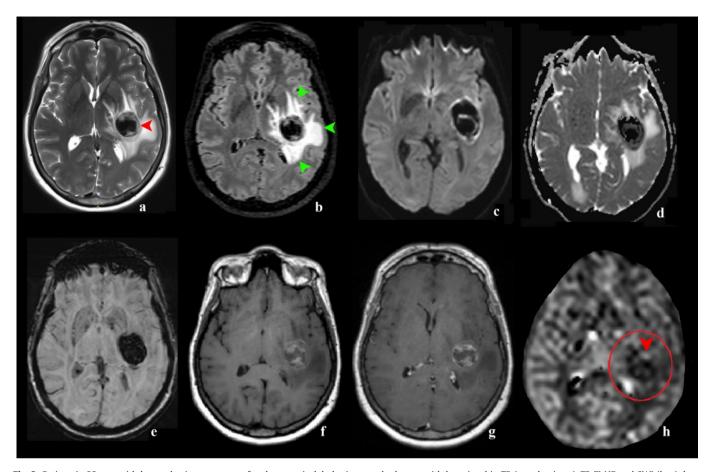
Patient A., 32 y.o., with hemorrhagic metastases of melanoma. A globular intracerebral mass with low signal in T2 (a, red pointer), T2 FLAIR and SWI (b, e) due to biological products that detect hemoglobin in the acute and early subacute phase after hemorrhage. Low T2 signal from the blood creates signal dropout (or "blackout") signals on the b = 1000 DWI and ADC map (c and d), visually increasing the size of the lesion. A tumor with pronounced perifocal vasogenic edema in T2 and T2 FLAIR (a and b, green arrows), a mass effect in the form of compression of the left lateral ventricle, small structural dislocations of the midline structures and smoothness of the subarachnoid space. Pre- and post-contrast T1 images (e and g) without obvious enhancement, however, on the raw ASL perfusion data (h) against the background of the dropped signal, a single focus of CBF measurement can be detected in the anterior outer parts of the metastasis (red pointer inside the red circle).
